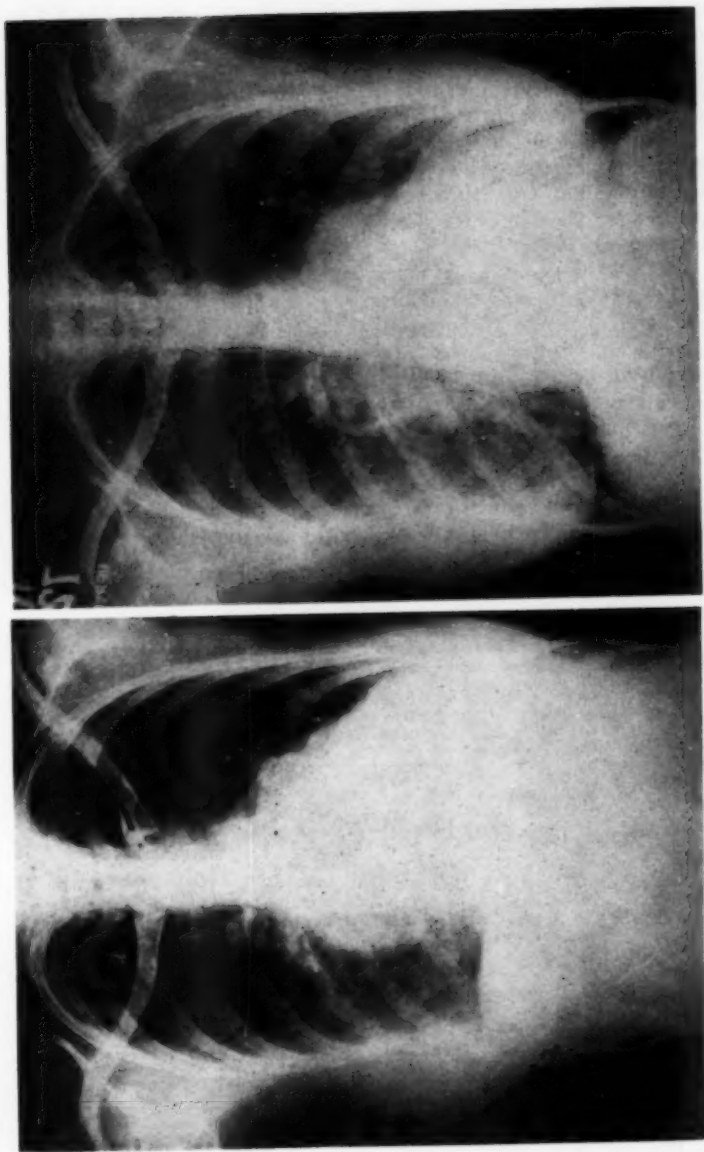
(*left*) Preoperative x-ray of heart of patient 10. (*right*) Postoperative x-ray of heart, showing some decrease in transverse diameter.
